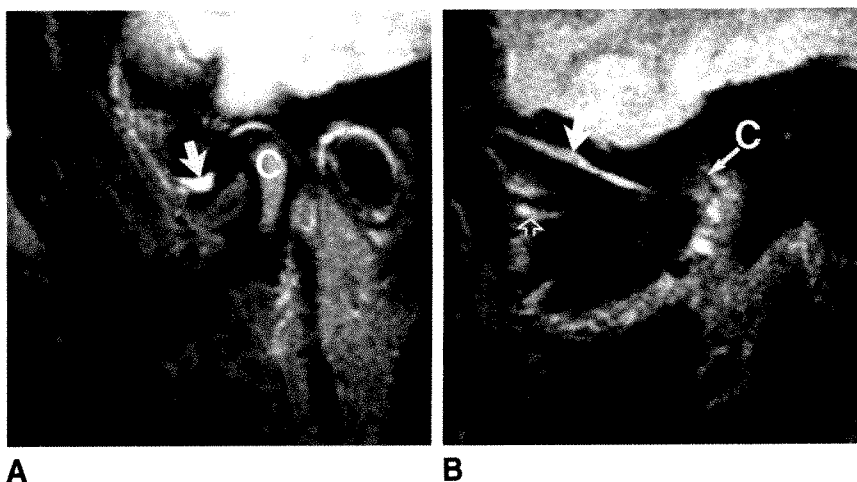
Fascial-space edema caused by non-infectious, inflammatory TMJ arthropathy in adult woman with recent onset of facial/TMJ pain, otalgia, and ipsilateral open bite. Closed-mouth, adjacent, sagittal MR images, 2500/100, through center of condyle (A) and medial pole of condyle (B). A, Large, signal-intense, upper-compartment effusion (arrow) is present. C = mandibular condyle. B, Fluid is seen above (solid arrow) and below (open arrow) superior belly of right lateral pterygoid. C = medial pole of condyle.
